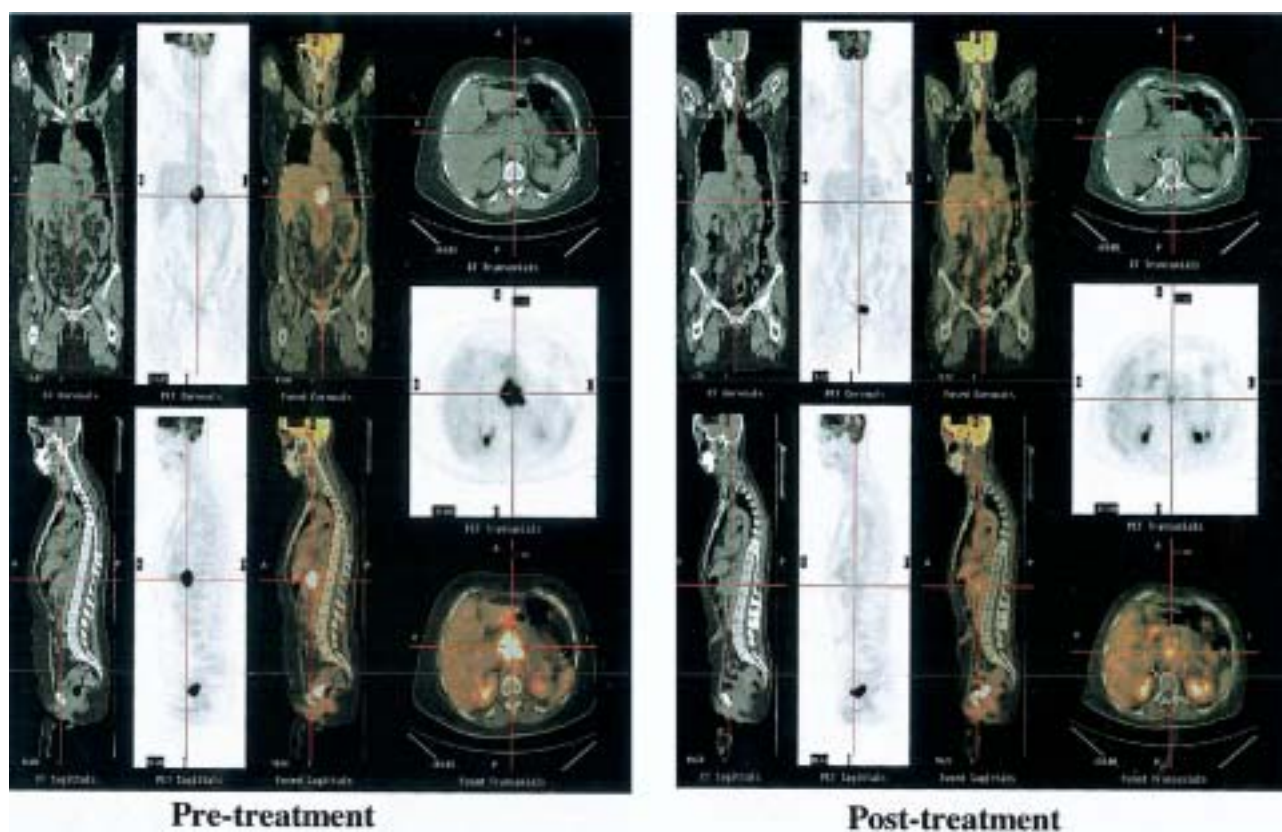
FDG-PET images of a pancreatic patient before and after radiation therapy.
